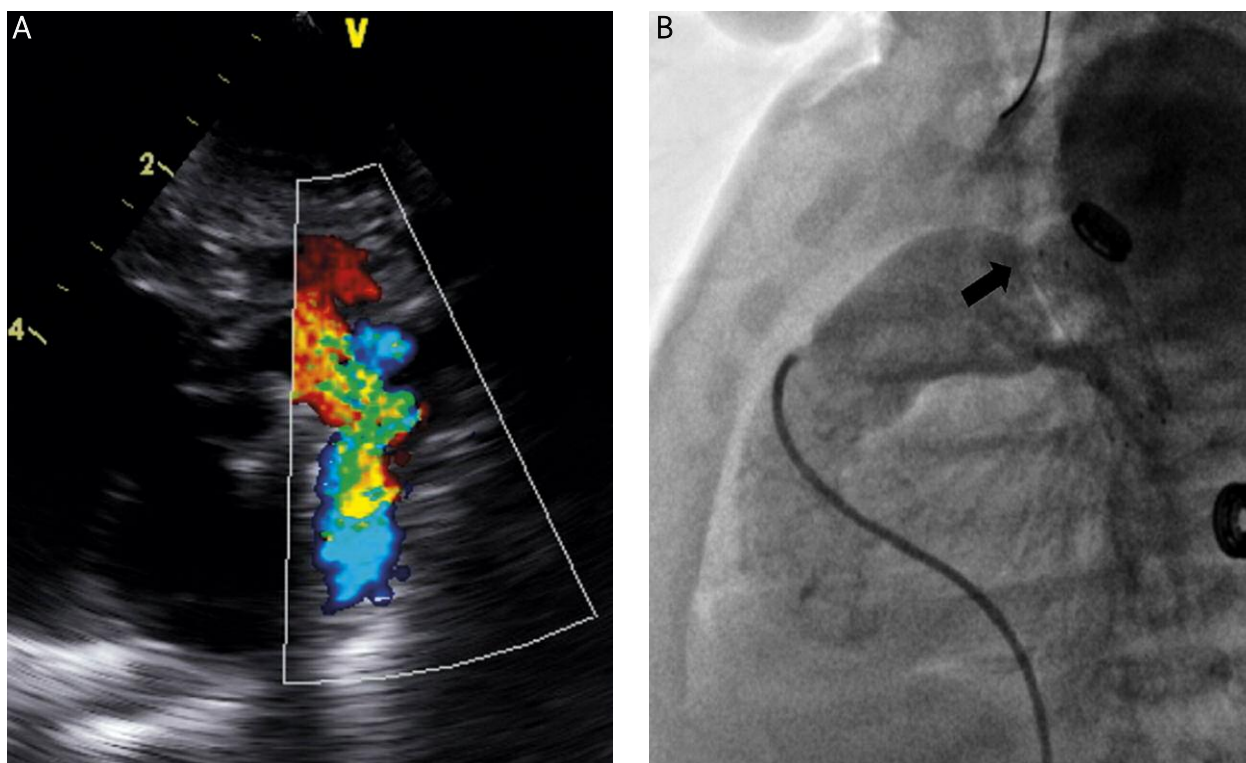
Proximal ductus arteriosus stenosis after the hybrid stage I procedure in a newborn with hypoplastic left heart syndrome. A – Echocardiography – restrictive blood flow through ductus arteriosus. B – Ventriculography – proximal stenosis of unstenated part of the ductus (arrow)
